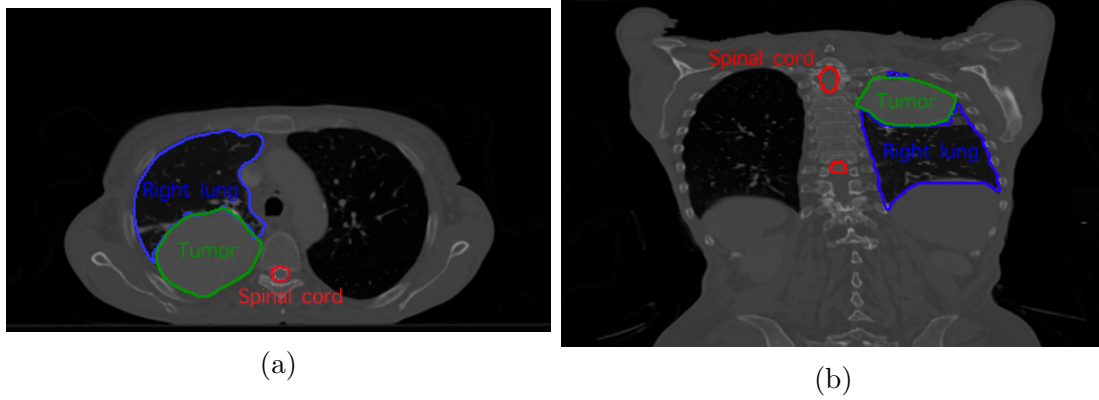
Delineation of the tumor and the OARs overlaying a patient CT image (left: transverse plane, right: coronal plane): in green the tumor, in red the spinal cord and in blue the right lung.
